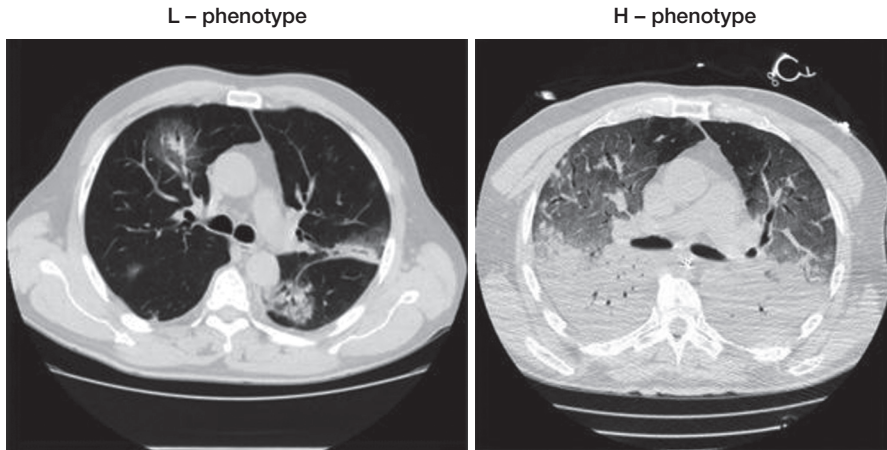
Chest CT scans demonstrating the difference between L-type and H-type ARDS.⁵¹
